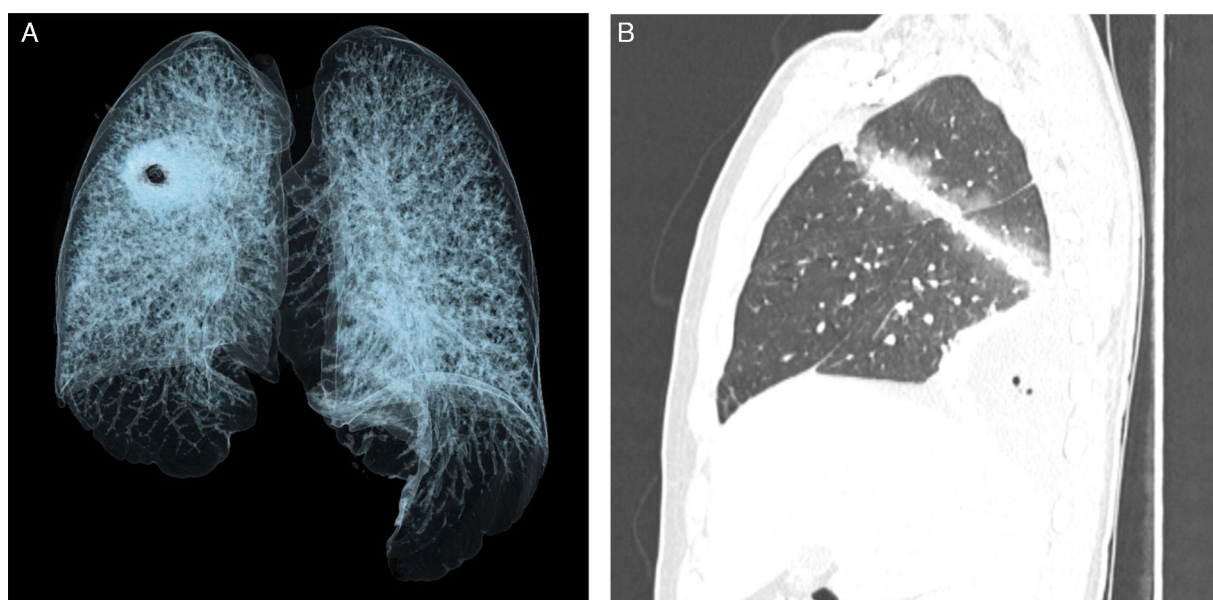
(A) The image shows a 3D reconstruction of a coronal chest CT scan showing the bullet entry wound. (B) The image shows a sagittal CT scan of the chest, revealing an oblique trajectory of the projectile from the anterior segment of the upper lobe to the apical segment of the lower right lobe, associated with moderate haemopneumothorax.
